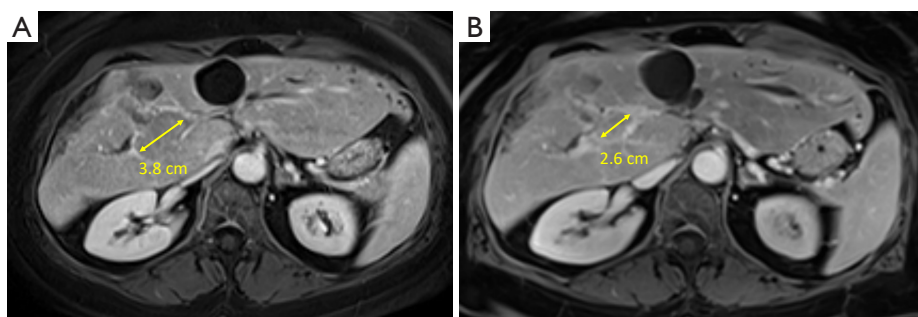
Changes in size of the primary lesion showing SR 4 months after relapse. CT imaging 6 months after diagnosis with axial views demonstrating (A) tumor thrombus within the main portal vein and right portal vein branches measuring up to 3.8 cm (LR-TIV) and (B) 4 months later after COVID-19 reinfection showing decreased tumor in vein lesion, now measuring 2.6 cm. SR, spontaneous regression; CT, computed tomography; LR-TIV, Liver Imaging Reporting and Data System tumor in vein; COVID-19, coronavirus disease 2019.
